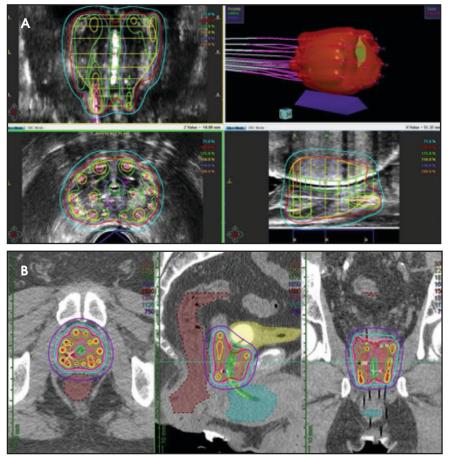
Clinical dosimetry of ultrasound-based (A) and CT-based (B) high dose rate (HDR) brachytherapy planning.
